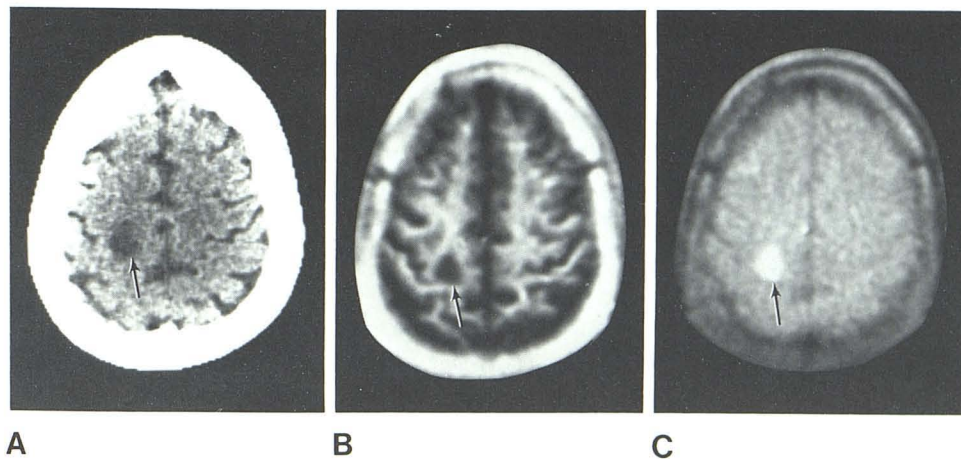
Chronic infarction. A, CT. B, IR_{1400/400}. Most of infarcted area seen as long T₁ region on B. However, smaller region with loss of gray-white matter contrast alone posterior to this region (small arrows) corresponds to smaller area of infarction on CT scan (large arrow).
